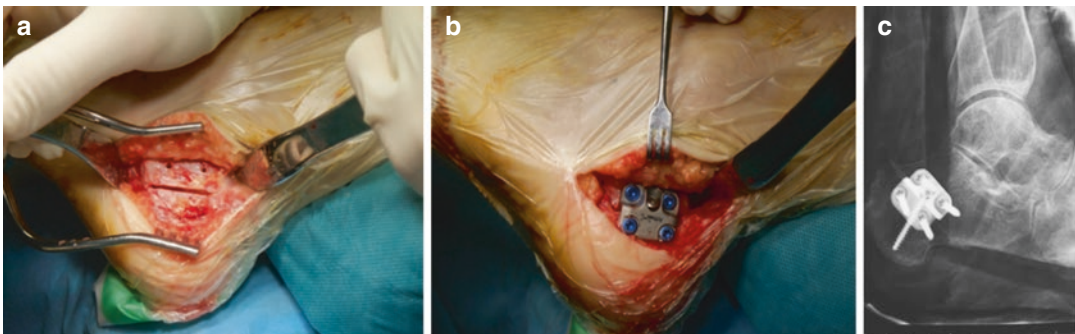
Surgical approach (a and b) and x-ray (c) of medial sliding calcaneal osteotomy
